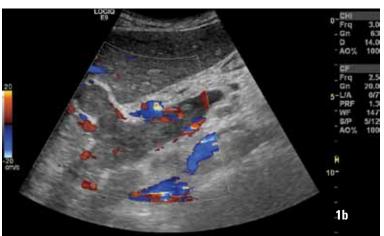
B-mode image (a) demonstrating echogenic material within the lumen of the anterior and posterior right portal veins. Colour Doppler image (b) demonstrating poor colour fill in the same areas. Ultrasound appearances are consistent with thrombus in the portal vein.
